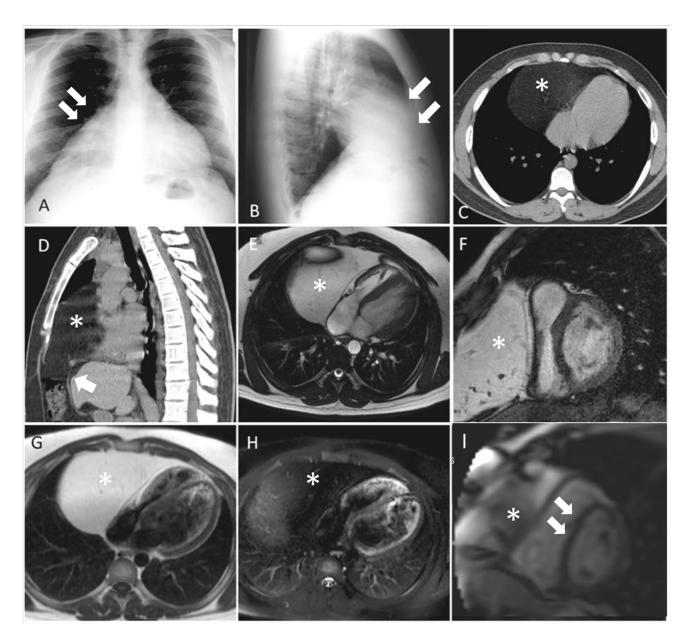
(A, B) Chest X-ray posteroanterior and lateral views showing a large right paracardiac opacity localized in the anterior mediastinum (arrows). (C, D) Axial and sagittal computed tomography images depicting a large diaphragmatic defect (arrow), with omental tissue in the retrosternal space (*); these are characteristics features of MH (*). (E, F) Axial and short axis steady-state free precession showing the heart dislocated leftward with compression of the right ventricle free wall from the MH (*). (G) Turbo spin echo black blood proton density axial image showing the hyperintense signal of fat tissue (*), with vascular structures inside. (H) Homogeneous signal suppression (*) on short T2 inversion recovery T2-weighted axial image. (I) Real-time cine short axis image emphasizing the pseudoconstrictive setting, with ventricular septal bounce and flattening during inspiration (arrows), compromising left ventricular filling. MH = Morgagni hernia.
